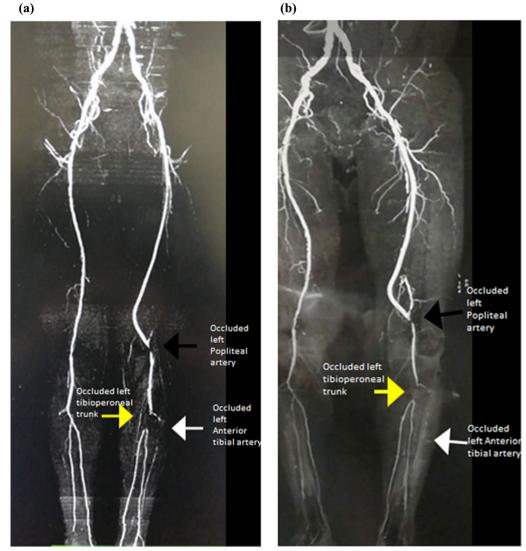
Case radiographs of magnetic resonance angiography (A) and computed tomography angiography (B) showed a patient with synthetic graft occluded at left popliteal artery (black arrow), occluded left tibioperoneal trunk (yellow arrow), occluded left anterior tibial artery (ATA) (white arrow)
